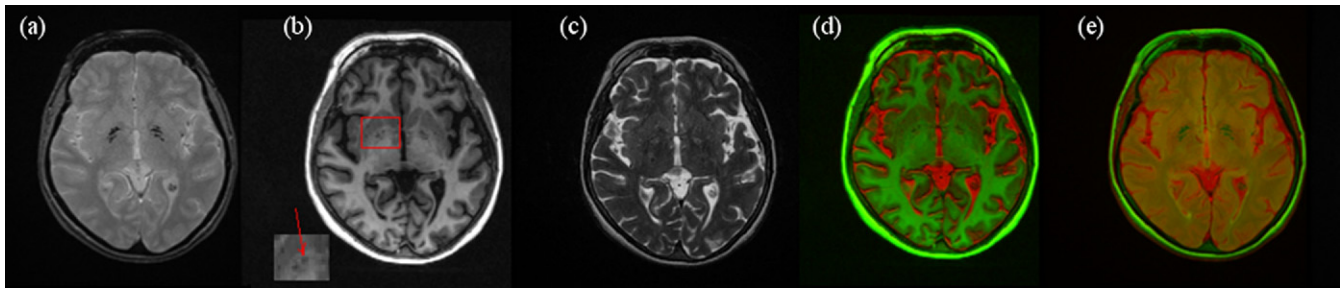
Example case with iron deposition with calcium. Central axial slice of a subject displaying from left to right: (a) T2*-weighted (T2* W), (b) T1-weighted (T1W), (c) T2-weighted (T2W), and (d) the registration and fusion results of T2W and T1W, and (e) T2* W and fluid-attenuated inversion recovery (FLAIR) images. The low signal on the T1W image (b) indicates that calcium is present as well as iron (inset).
